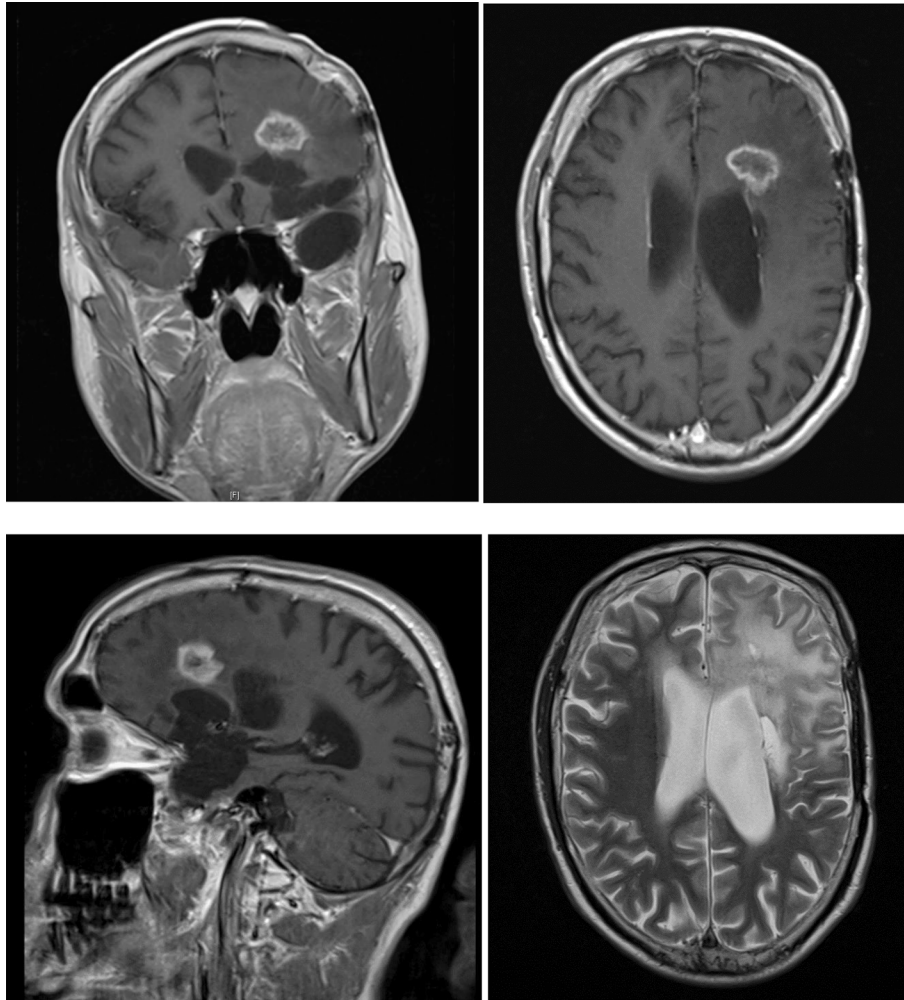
May 2019: MRI (T1 with contrast coronar, axial, sagittal and T2 axial), suspected progress after radiation.
